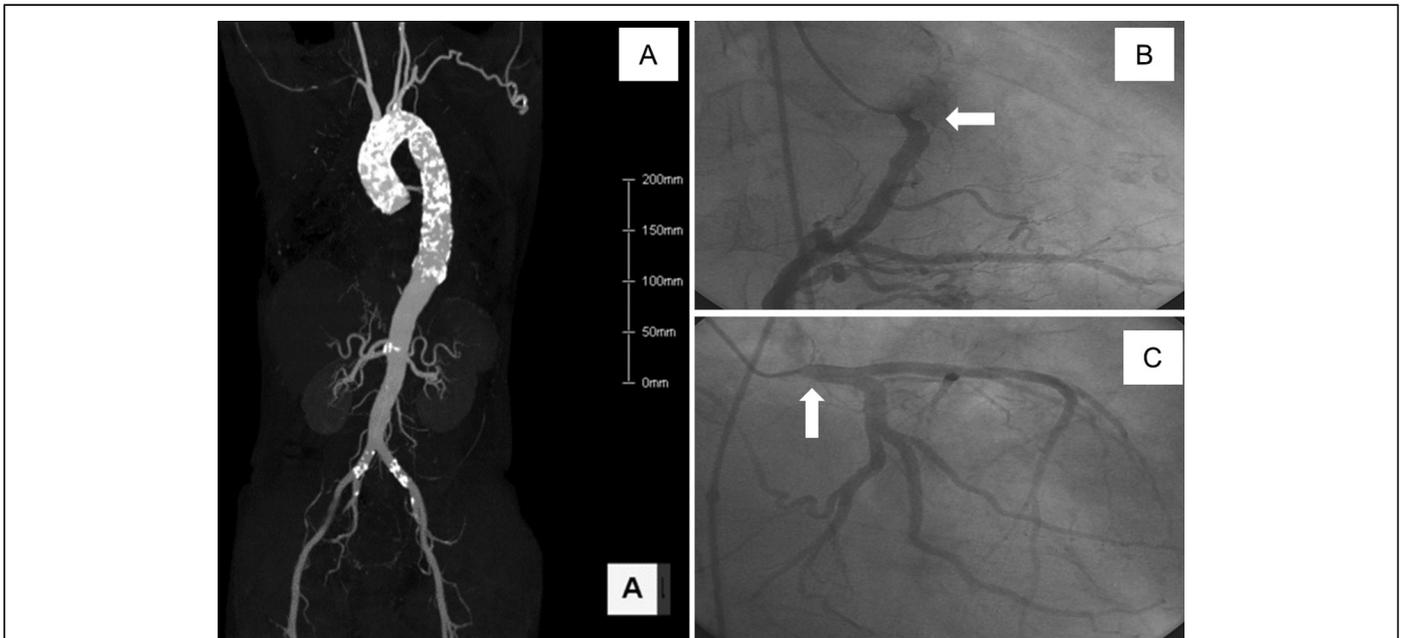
(A) Preoperative enhanced computed tomography showed the porcelain aorta. (B) Preoperative right coronary selective injection revealed 75% stenosis in the ostium of right coronary artery (arrow). (C) Preoperative left coronary selective injection revealed 75% stenosis in the ostium of left main coronary artery (arrow).
